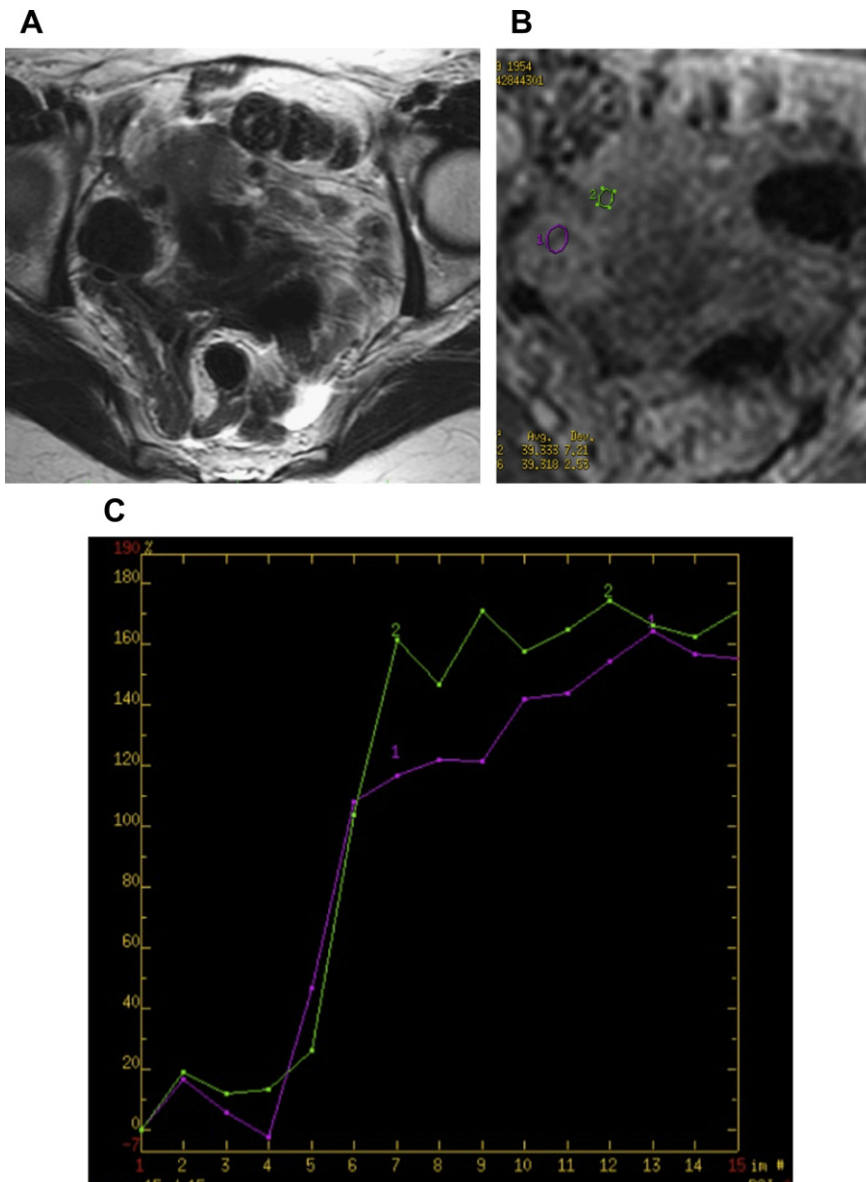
Ligament right leiomyoma. DCE-MR imaging shows stronger enhancement in the leiomyoma compared with myometrium, with type III curve. (A) Axial T2-weighted image. (B) DCE-MR imaging. (C) Dynamic curve.
